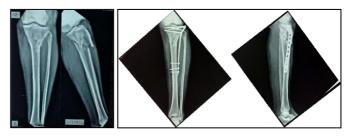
Preoperative and immediate post-operative radiograph of intra-articular proximal tibia fracture in anteroposterior and lateral views.
